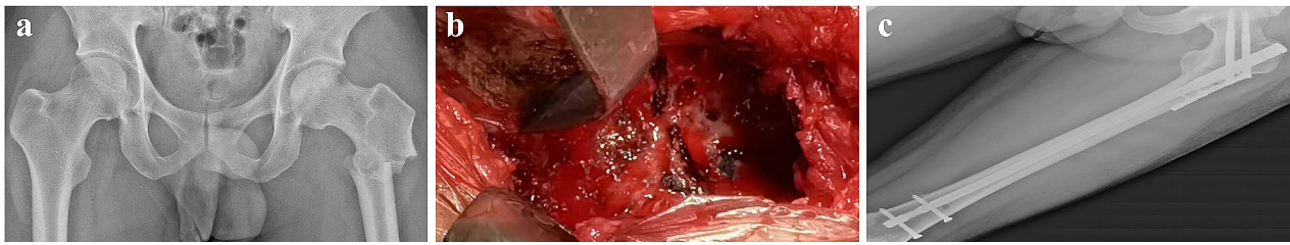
a shows the patient's preoperative plain radiograph of the pelvis, b shows the intraoperative situation, and c shows the postoperative full-length plain radiograph of the femur
